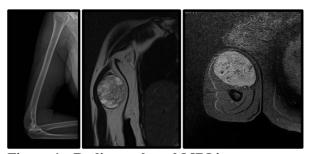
Radiograph and MRI images.
